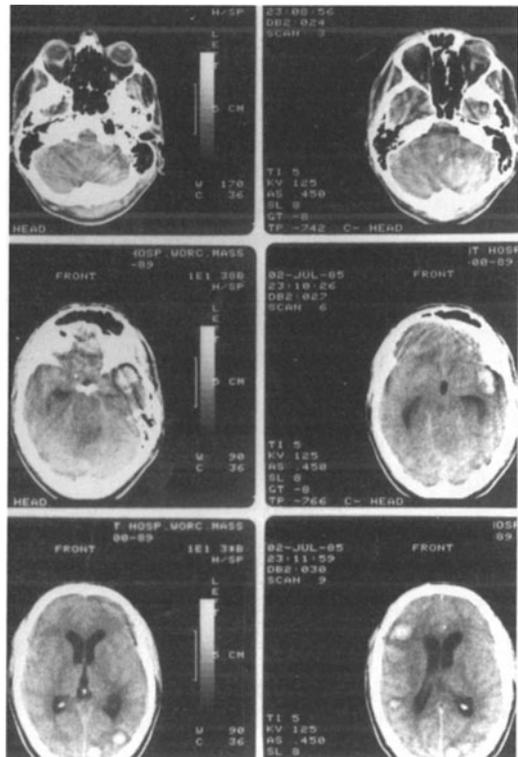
Multiple cerebral hemorrhages secondary to acute thrombocytopenia (platelet count of 17,000) with acute lymphatic leukemia. CT scan without contrast in a 24 year old with headache and acute onset of coma, clinical brain death and a flat EEG.
